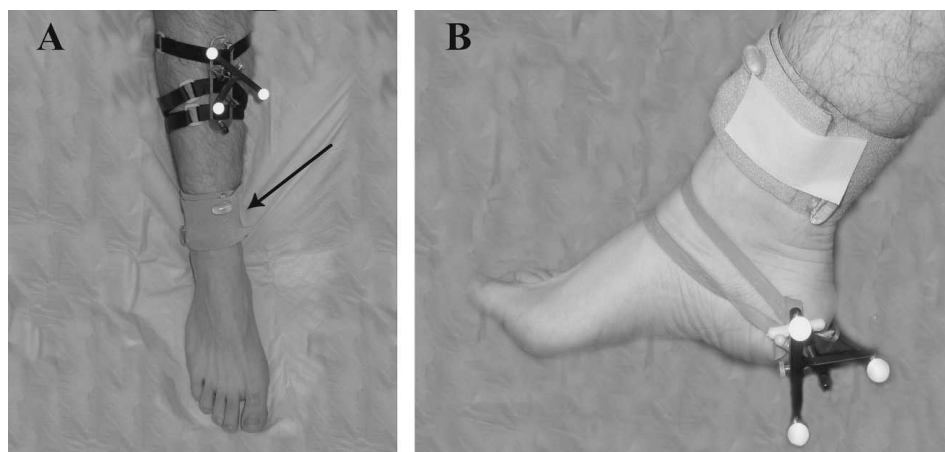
(A) Passive reference frames were attached to subjects with a metal bracket and straps. A neoprene cuff with vitamin E tablets (arrow) was used to register the experimental data to the MR images. (B) A reference frame is attached to a subject's calcaneus to record motion data for the kinematic methods.
